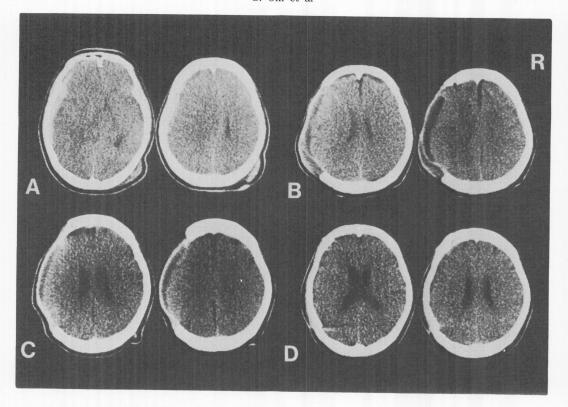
Serial CT scans of Case 1
